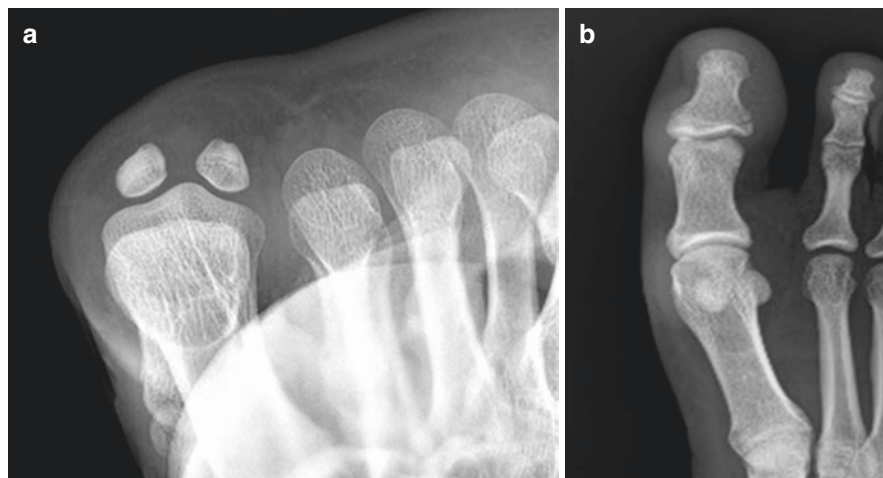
(a) X-ray sesamoid view of first MTP joint showing tibial and fibular sesamoids with intervening crista. (b) X-ray of foot oblique view showing normal position of sesamoids
